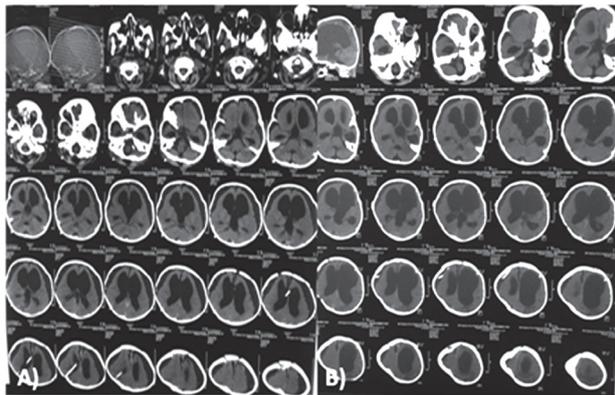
A) Post Op CT scan brain showing B/L subdural effusion with V-P shunt in situ, B) CT scan brain showing B/L subduro- peritoneal shunt and regressed subdural effusion
